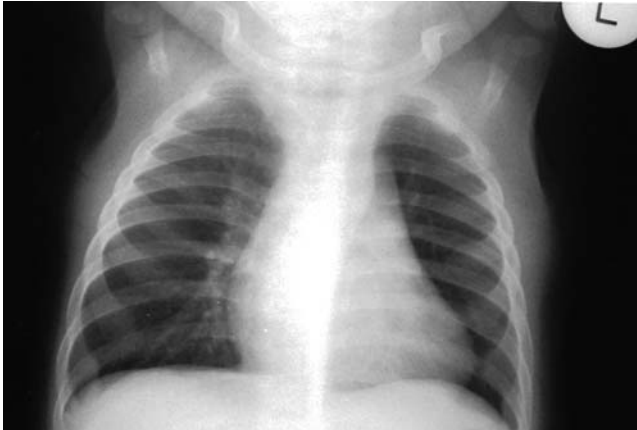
Normal follow-up AP chest radiograph one day after admission.
